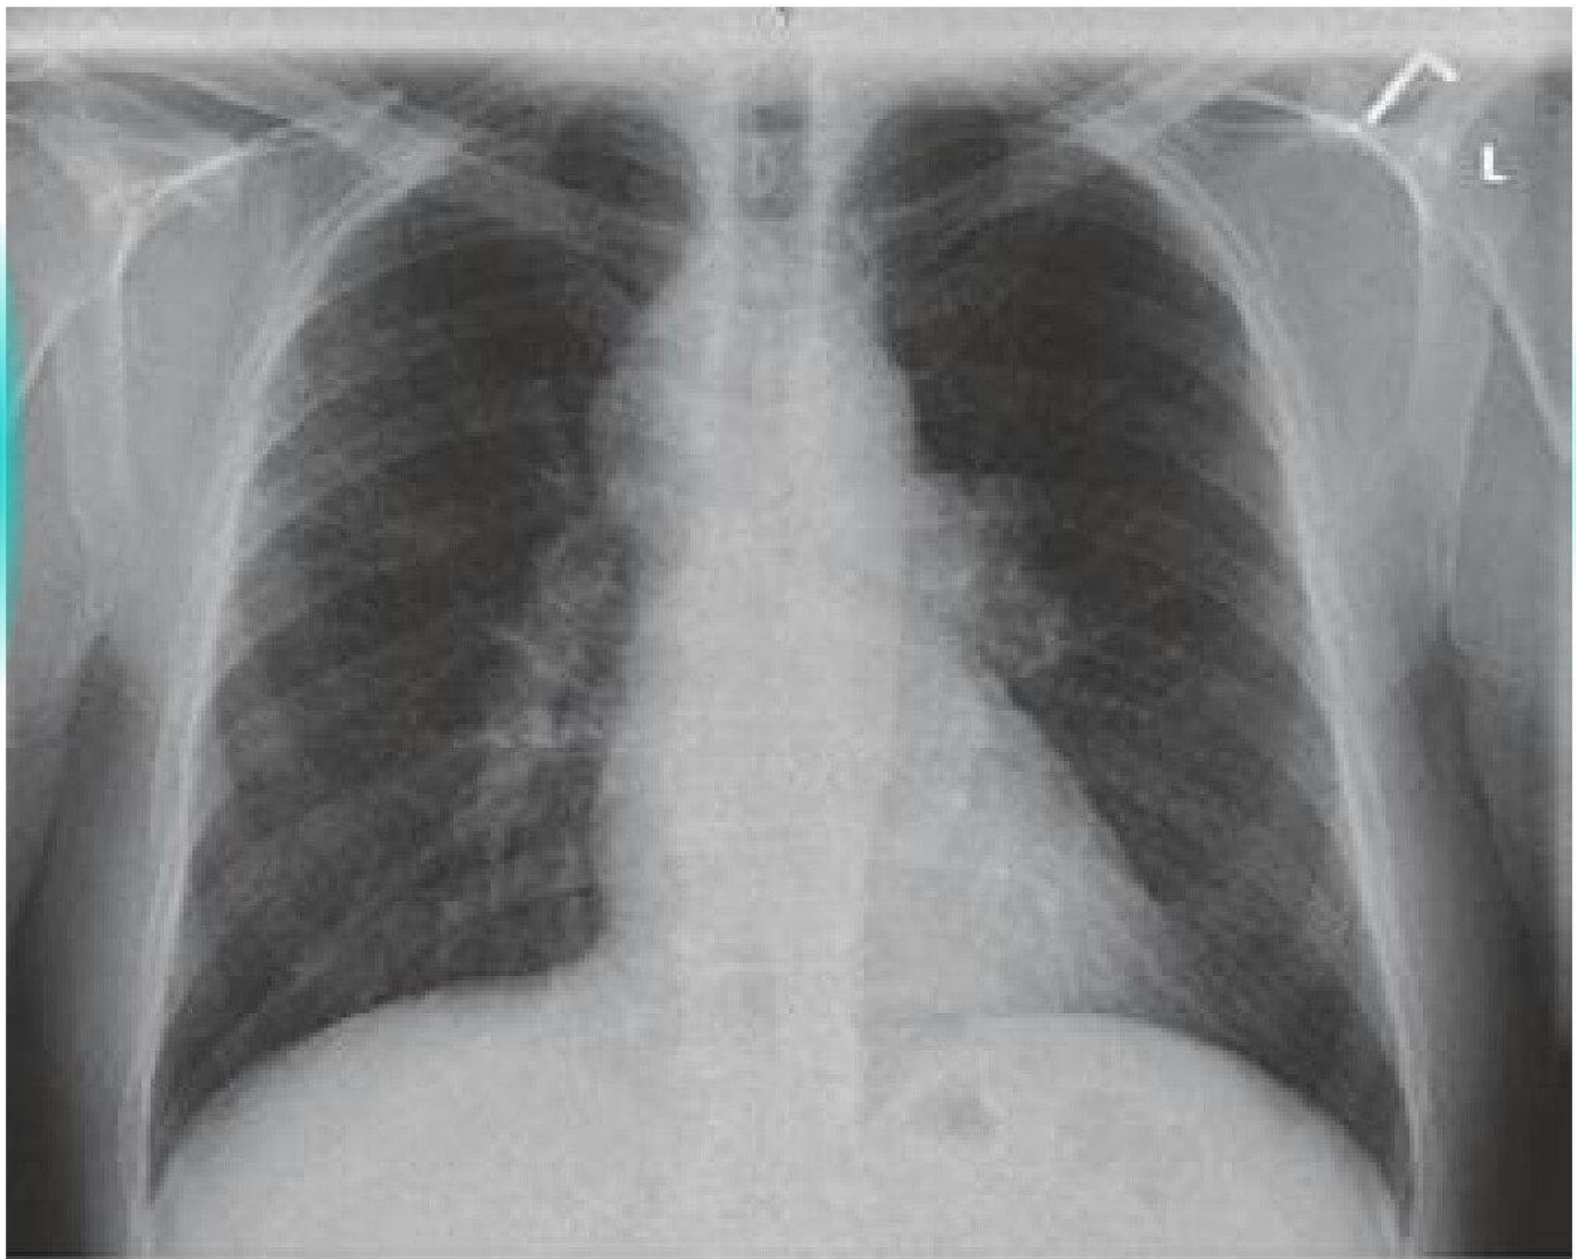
Posterior-anterior chest roentgenogram demonstrating bilateral hilar adenopathy, stage 1 disease.
